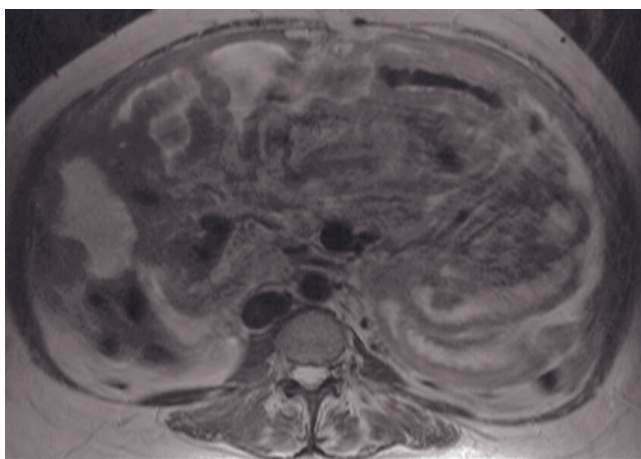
(*Continued*) SGE (*g*), and fat-suppressed T1-weighted postgadolinium SGE (*h*) images in a third patient with ovarian cancer demonstrate large nodules consistent with peritoneal seeding (arrow, *f*). T1-weighted fat-suppressed interstitial phase postgadolinium axial (*i*, *j*, *k*) and sagittal (*l*) 3D-GE images at 3.0 T demonstrate thin platelike (white arrows) and small nodular (black arrow) peritoneal metastases in another patient. T2-weighted single-shot echo-train spin-echo (*m*) and T1-weighted fat-suppressed
